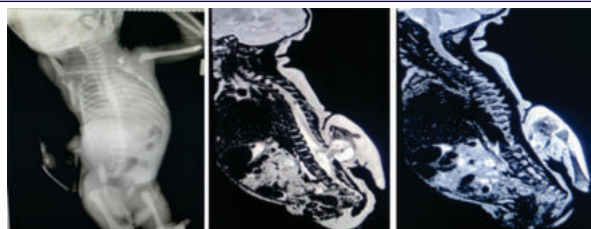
X ray, and MRI Images Showing Herniation Of Meninges Into Accessory Limb.
